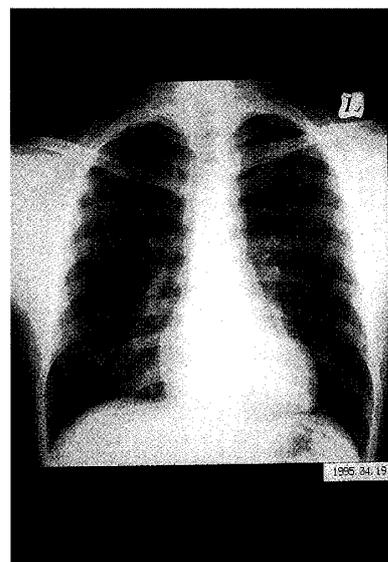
Chest radiograph showing improvement of the mass shadow in the right upper lung.
